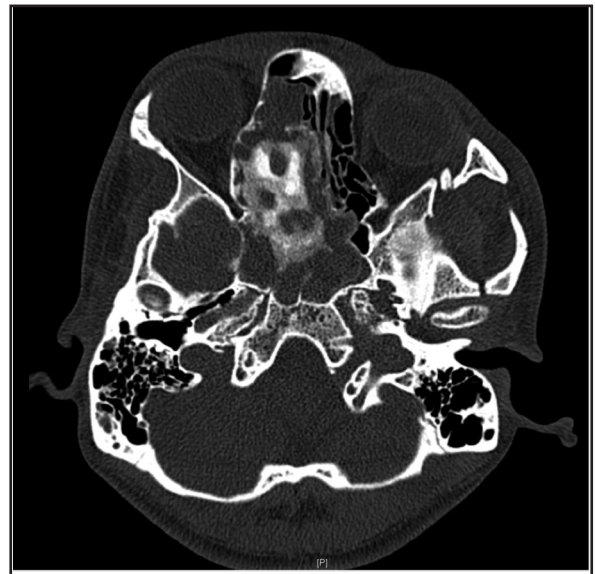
CT scan showing osteoma involving the right ethmoid and sphenoid sinuses, measuring about 3.1 x 2.0 x 2.6 cm (W x AP x CC).
